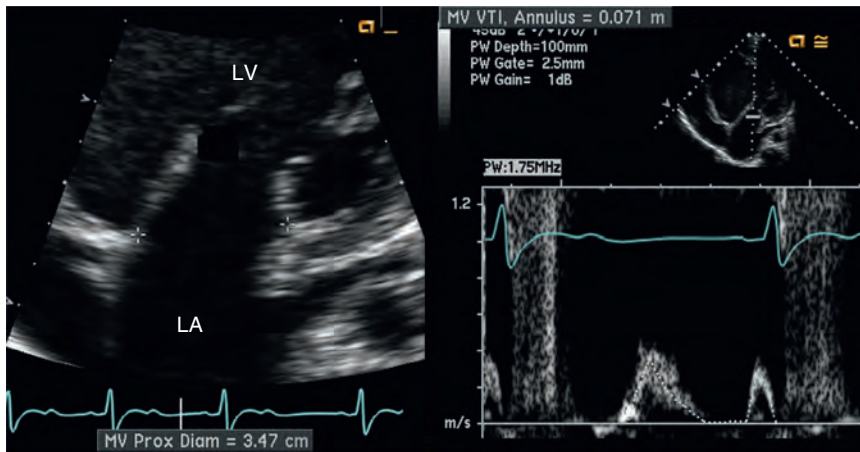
Doppler transmitral stroke volume calculation. The mitral valve (MV) annulus area in diastole is multiplied by the velocity-time integral (VTI) of flow at the annulus. In this example, annulus diameter (left) is 3.5 cm, so the circular cross-sectional area is 9.6 cm². The velocity-time integral of transmitral flow is 7.7 cm for a stroke volume of 74 mL or a cardiac output of 4.4 L/min at a heart rate of 60 bpm.
